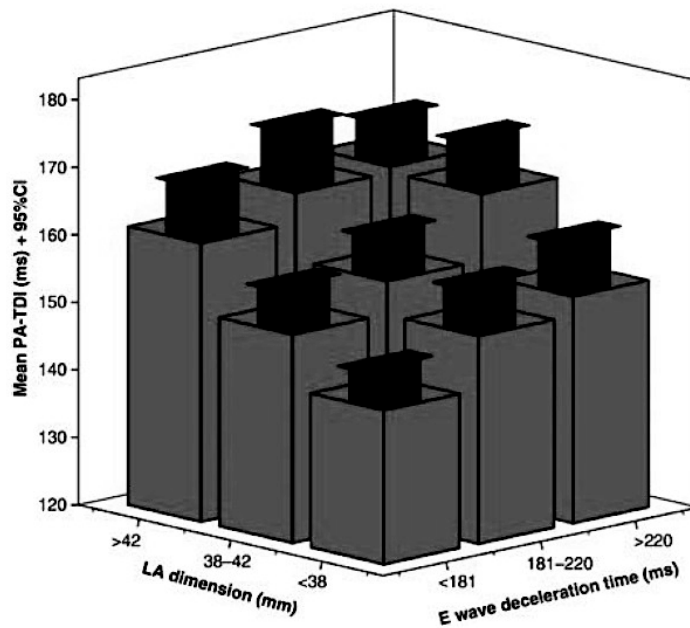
Echocardiographic parameters affecting the PA-TDI interval. Mean PA-TDI interval and 95% confidence intervals according to mitral valve E-wave deceleration time and left atrial dimension, both in tertiles.
